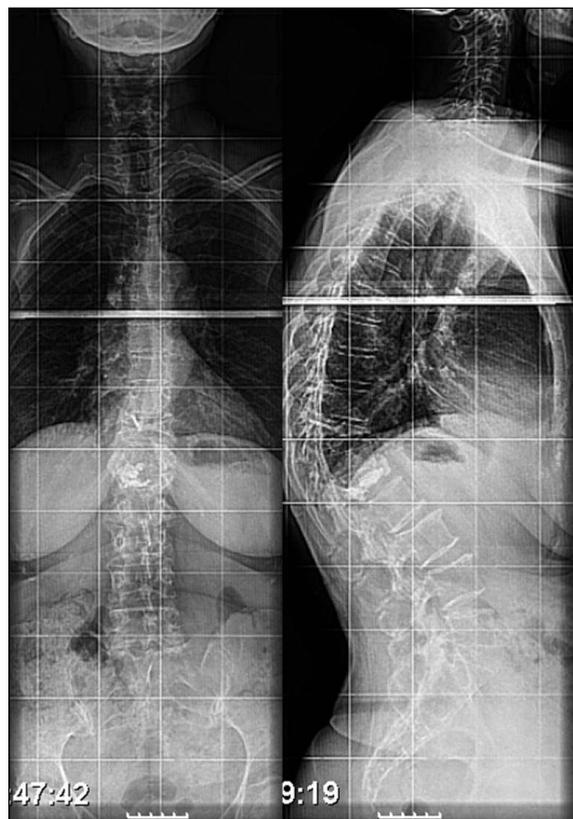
Pre op x-rays showing T11 and L1 fractures conditioning short segment deformity
